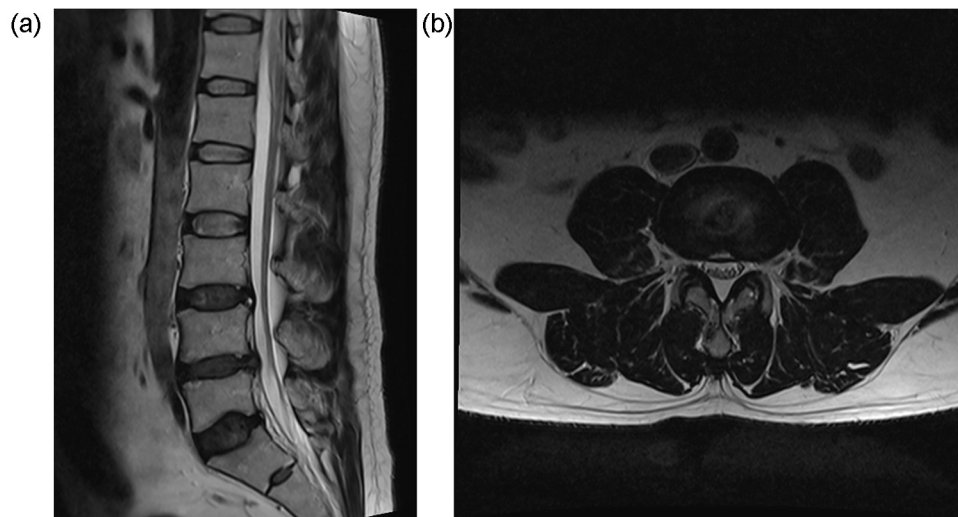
Lumbar disc herniation is seen to be resorbed on follow up Sagittal (A) and Axial (B) T2 weighted MRI of the lumbar spine at the L3–L4 level after 9 months.
